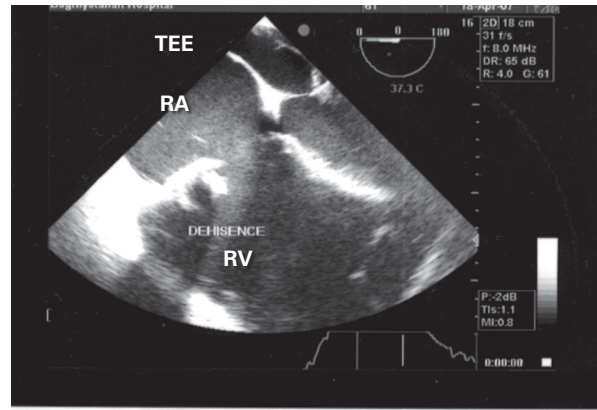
Transesophageal echocardiogram in 4-chamber view confirms dehiscence of the bioprosthetic tricuspid valve.
